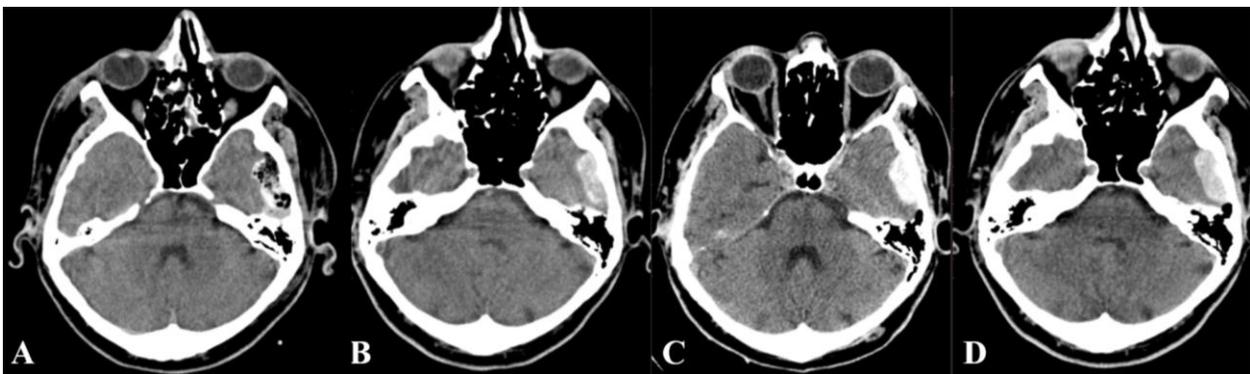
The follow-up cranial CT scan performed after 1, 2 and 3 years (B, C, D) revealed the hypervascular muscle graft mimicking a meningioma or other hypervascular lesions
